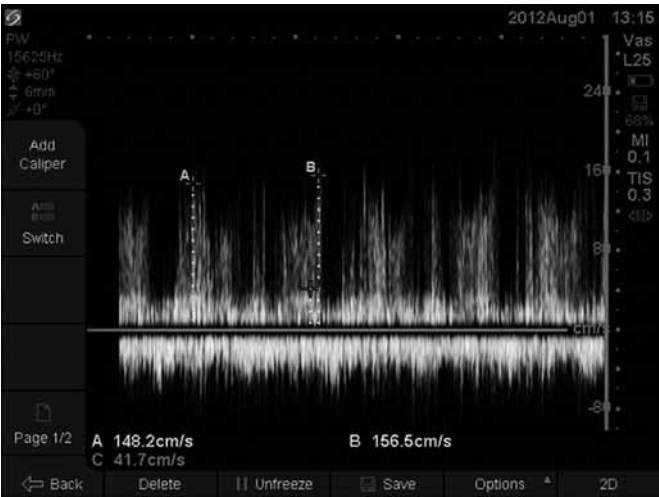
Ultrasound image for a mean velocity Doppler measurement at 4 cm from the needle tip at 400 mL/min.
